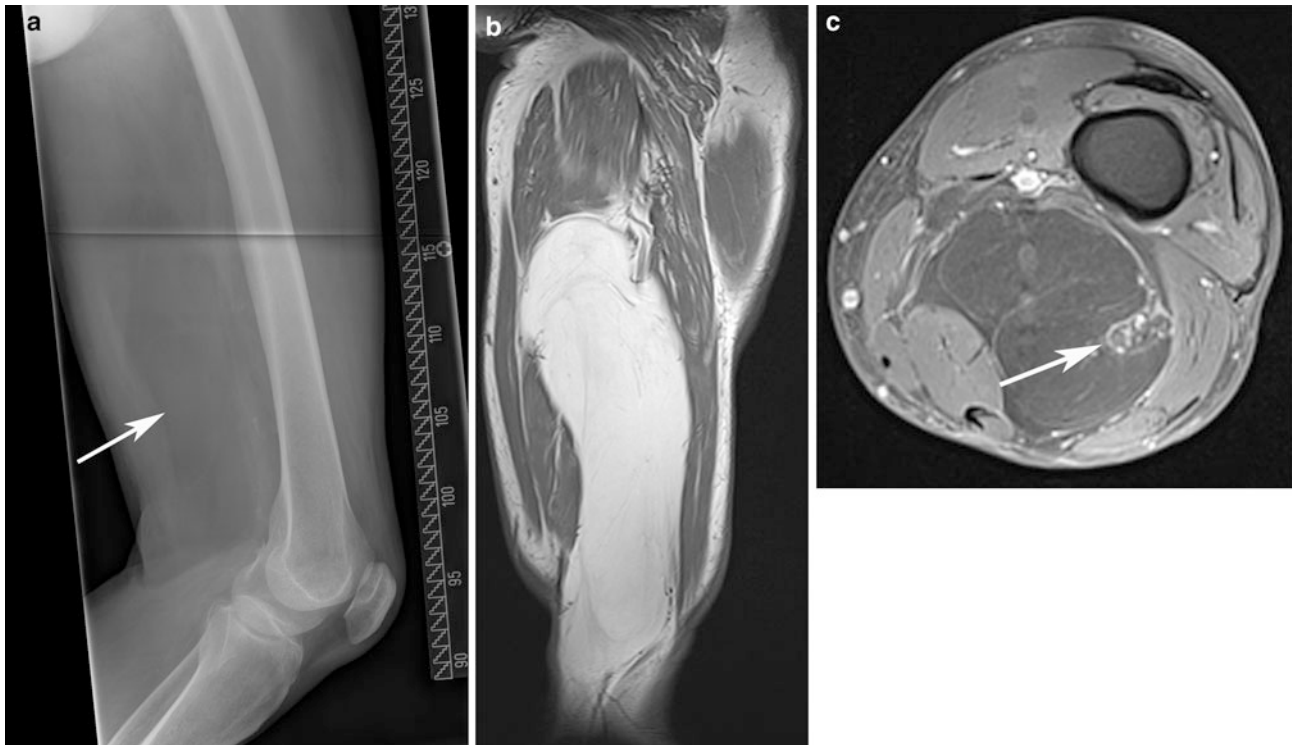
Large (about 20 cm) lipoma of the thigh with encasement of the sciatic nerve in a 74-year-old man. The lipoma is seen as radiolucency in the projection radiograph (*arrow* in a), appears homogeneous on the T1-weighted sagittal MR image b and encases
